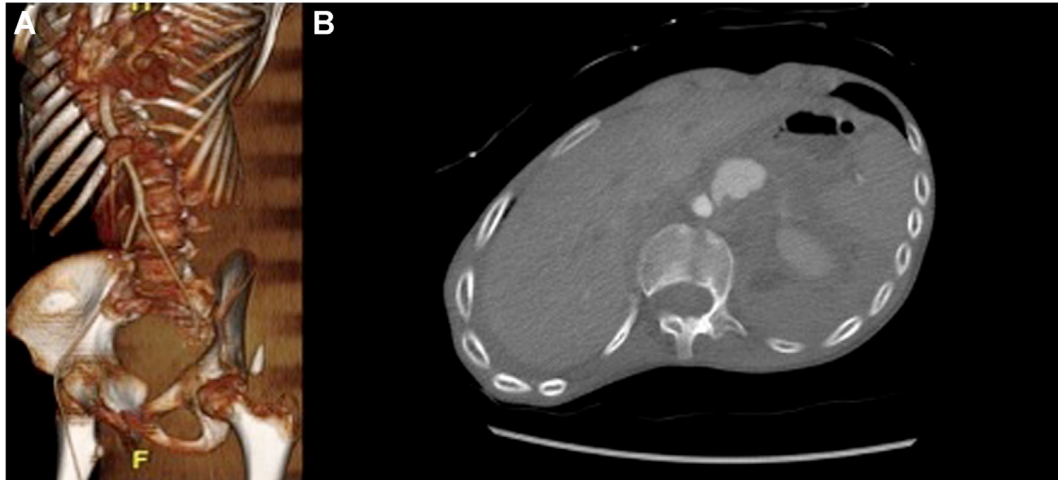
Patient 1. A, Computed tomography (CT) scan showing a celiac axis abnormality, retrospectively identified as an aneurysm, and severe spinal curvature. B, Repeat CT scan confirming celiac artery pseudoaneurysm rupture.
